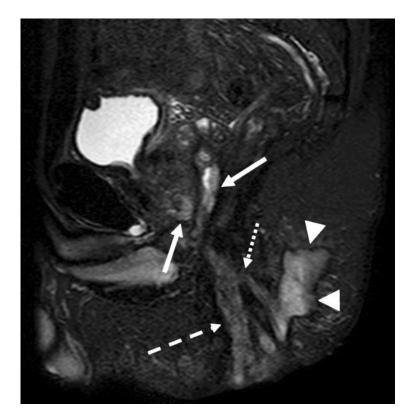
Sagittal T2-weighted image with fat-saturation
